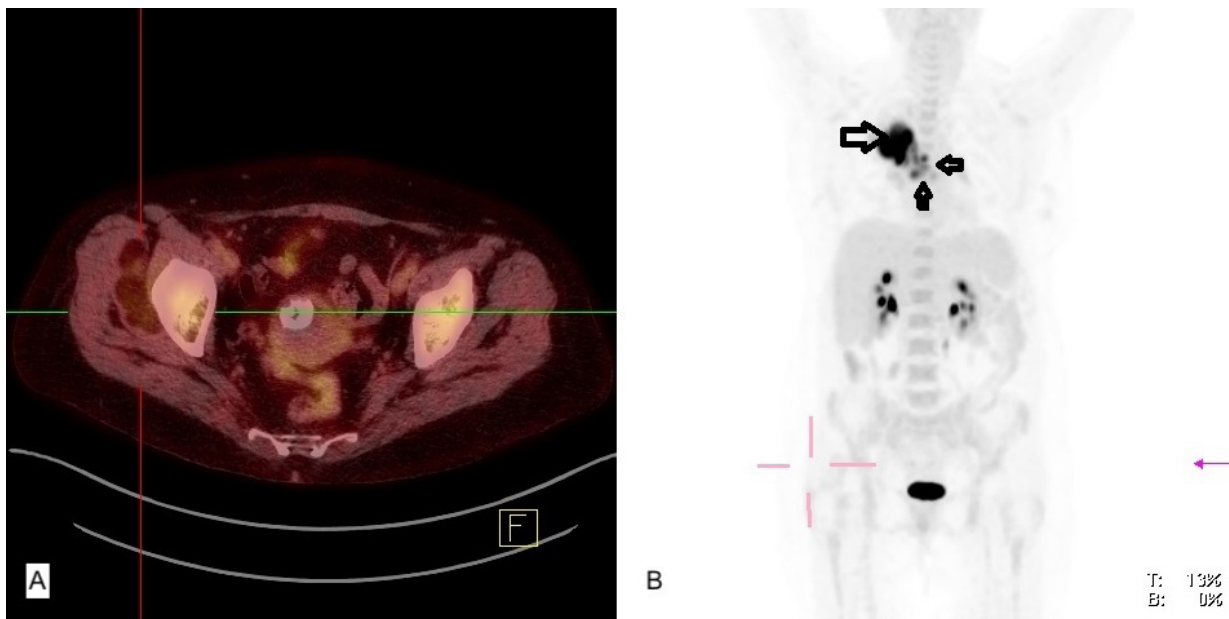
A, The axial fused ^{18}F -FDG PET-CT shows a non-FDG-avid fatty mass in the right gluteal region (hairline marker). A 45-year-old man with stage IIIB non-small cell lung cancer (NSCLC) underwent ^{18}F -FDG. B, (MIP PET): The first PET imaging on re-staging using ^{18}F -FDG PET-CT reveals an FDG-avid mass (SUVmax: 26.8 g/mL), measuring 6.9 cm \times 6.0 cm in the upper lobe of the right lung (head arrow), along with multiple areas of FDG-avid mediastinal lymphadenopathy (small head arrows).
